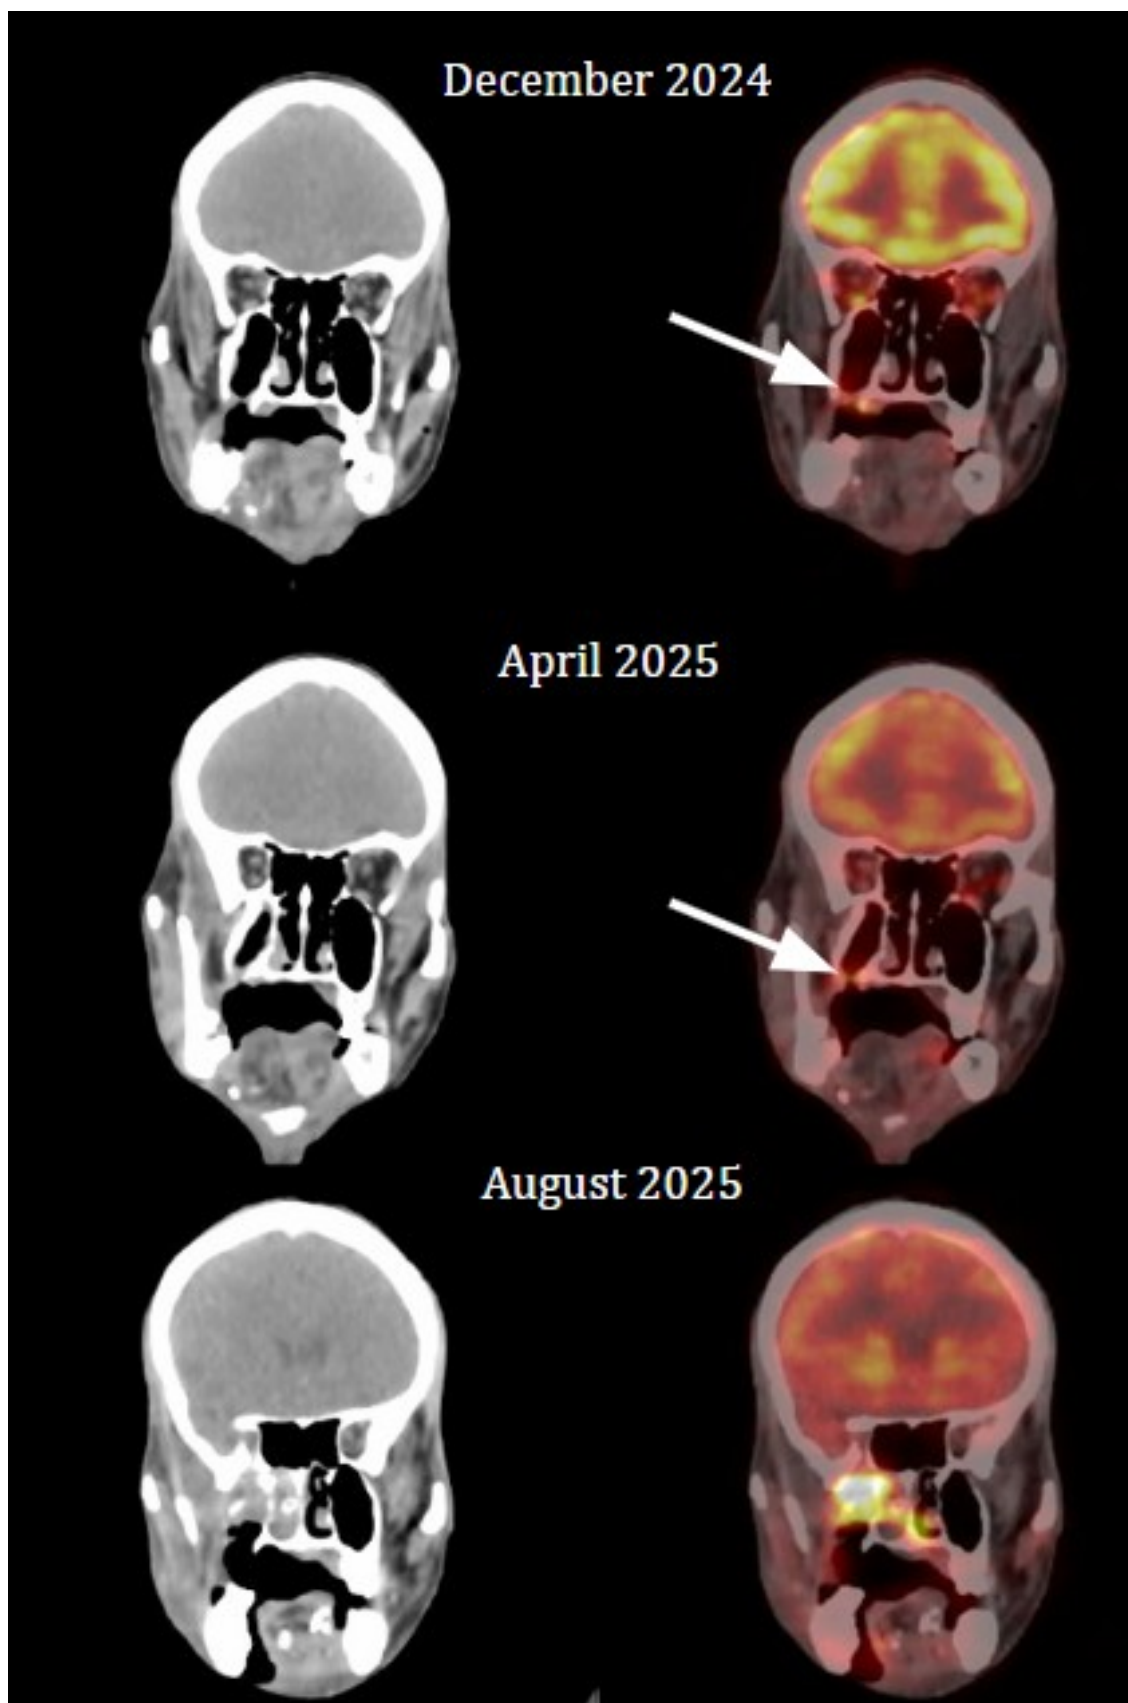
Coronal CT and fused PET/CT images, demonstrating the same subtle focal uptake along the floor of the right maxillary sinus on earlier scans, and the later destructive mass lesion seen in August 2025.
